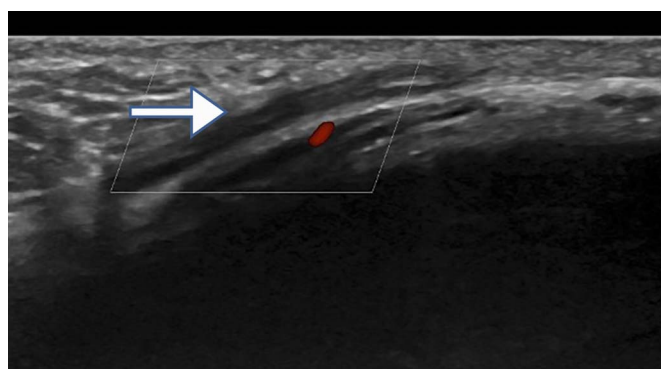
A 72-year-old man presents with Mondor disease of the penis. Sagittal color Doppler image shows a hypoechoic clot and absent color flow in the deep dorsal vein (arrow) of the penis.
